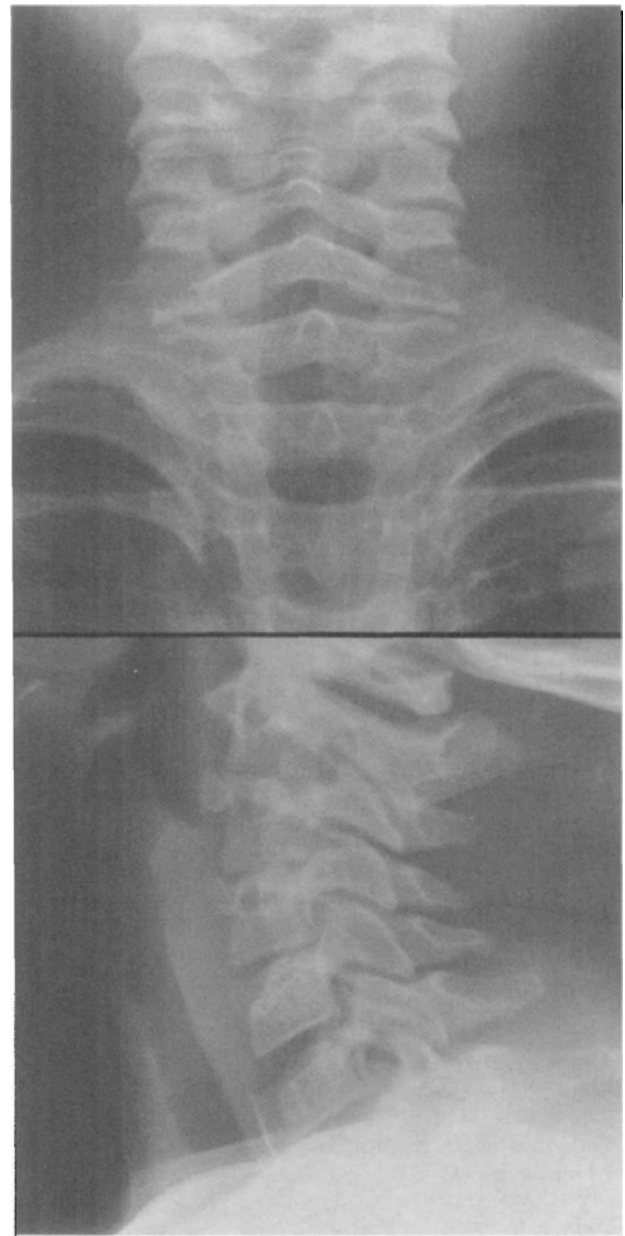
FIGURE (Top) Antero-posterior neck radiograph of the patient. (Bottom) Lateral neck radiograph of the patient.
